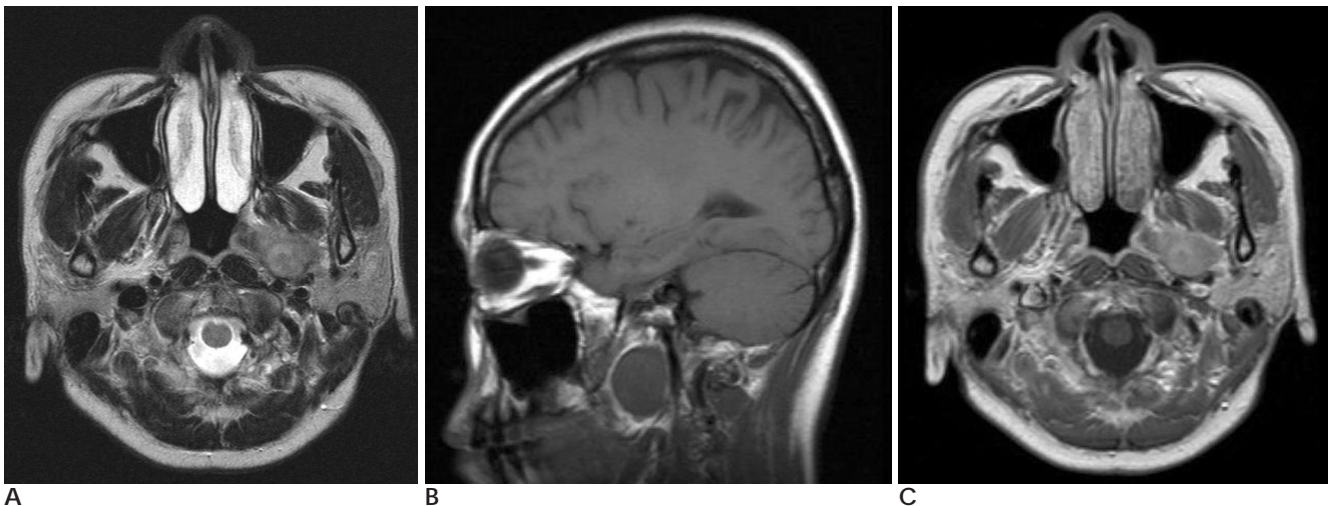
A 35-year-old woman presented with headache and dizziness; routine brain MR imaging was performed.
